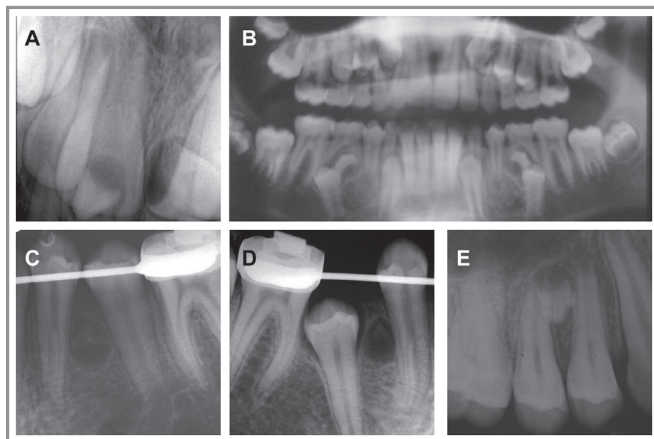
(A) Periapical radiograph showing 2 bilateral supernumerary teeth (ST) in the maxillary central incisor region. (B) Periapical radiograph showing 4 other ST, 3 years and 3 months later. (C, D, and E) Almost 2 years later, the development of a third generation of ST consisting of 3 supplemental teeth was seen on a panoramic radiograph.
